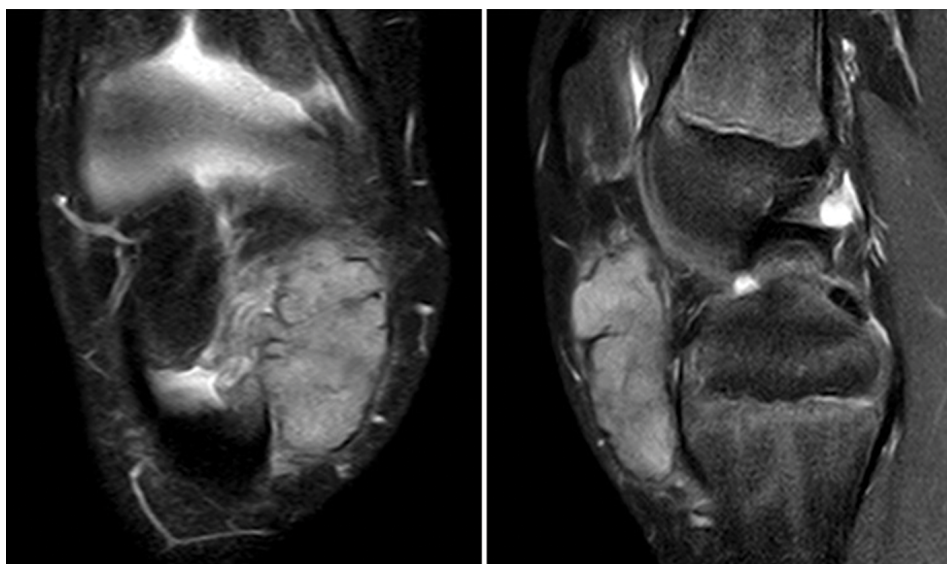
T-2 weighted MRI, coronal and sagittal planes, depicting the giant cell tumor of the patellar tendon sheath.
